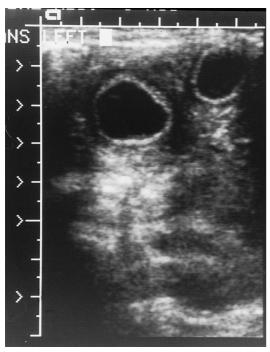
Abdominal ultrasound. Two cystic round masses, 2 and 3 cm in diameter, were demonstrated. Their wall consisted of an inner echogenic layer (mucosa) and an outer (muscle layer)
